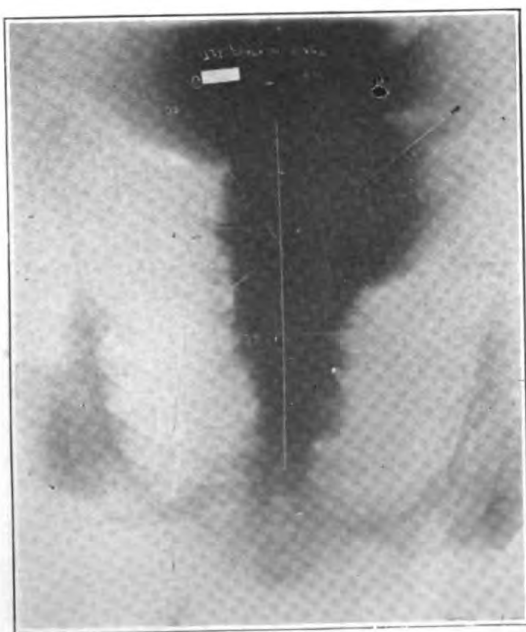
X-rays confirm the fluoroscopic observation, showing in addition a prominent aortic knob and a moderate dilatation in the region of the ascending aorta. Interpretation: Considering the age of the patient with definite increase in size of the aorta, in the oblique view and with distinct sharp cardiac outline, arteriosclerosis must be considered first and syphilitic aortitis second.
